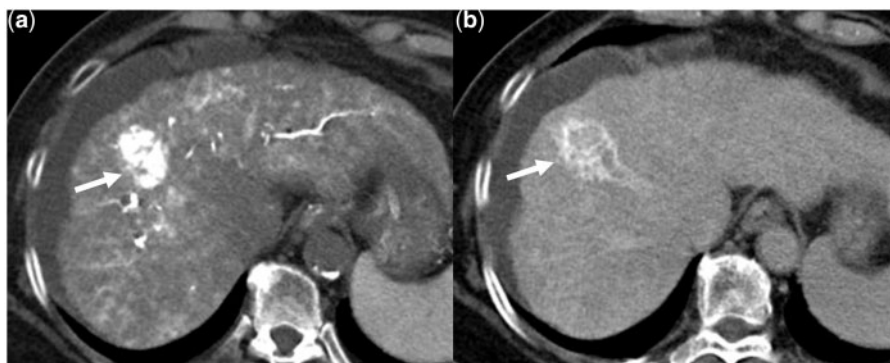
CT arteriography of HCC (arrow) in a 66-year-old patient with cryptogenic cirrhosis. Intense enhancement in the arterial phase (a) and washout in the central portion of the tumor in the delayed phase (b).
